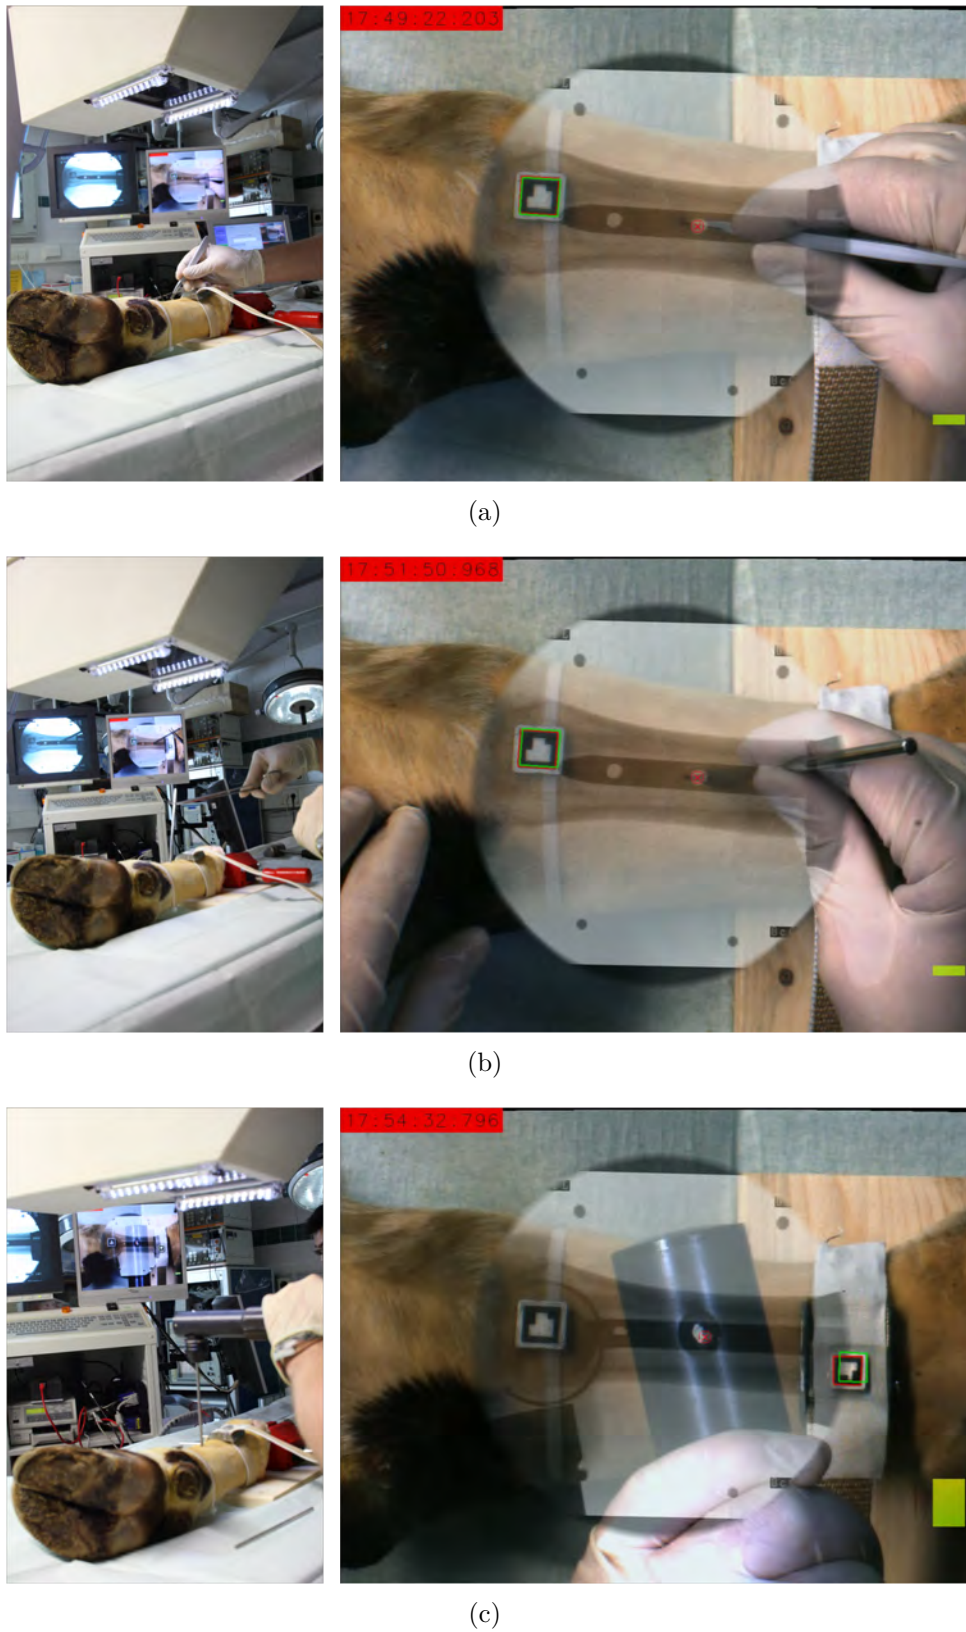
Skin incision (a), center punch (b) and drilling (c) tasks using video augmented X-ray images. The left images show the working scenario and the right images shows video augmented X-ray images seen in the monitor .
